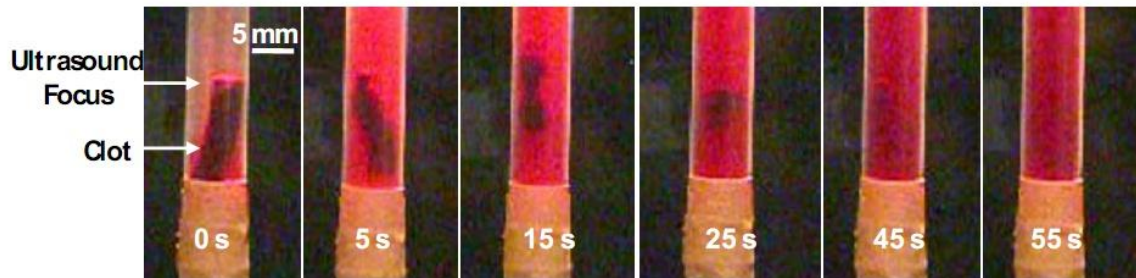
Progression of treatment in static saline. Ultrasound propagation is from right to left in the image. The clot moves into the focus of the transducer almost immediately after ultrasound exposure is started generated. The clot quickly loses mass and is bisected at the focus. Each of the two larger pieces is then dissolved over 45 seconds until no visible particles remain.
